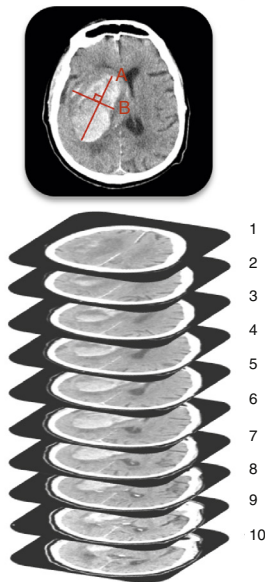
Calculating the volume of intracerebral hemorrhage from axial CT scan images.¹⁴
